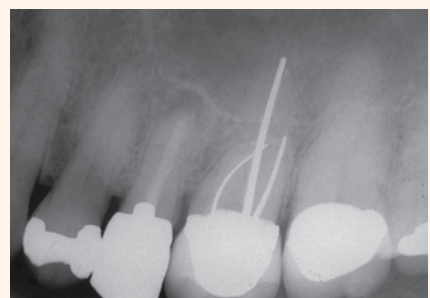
This radiograph demonstrates a 31-year success with delicate shaping and crude obturation with silver points (#14), and a four-year failure with a large crown-down shape and heated gutta-percha (note the lesion on #13).
